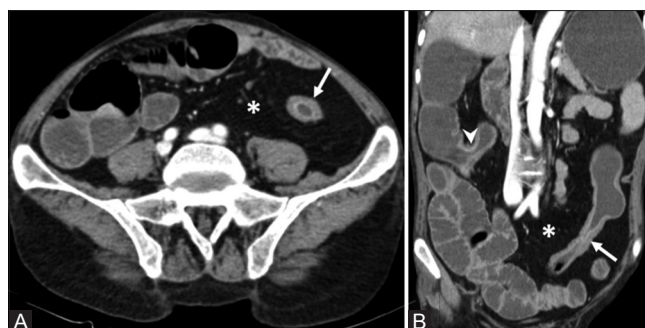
(A and B): Axial (A) and coronal (B) contrast-enhanced CT enterography images showing long-segment wall thickening and mucosal enhancement of descending colon (arrows) with increased visceral fat (asterisks). Another short-segment involvement of ileocecal junction is noted (arrow head)
